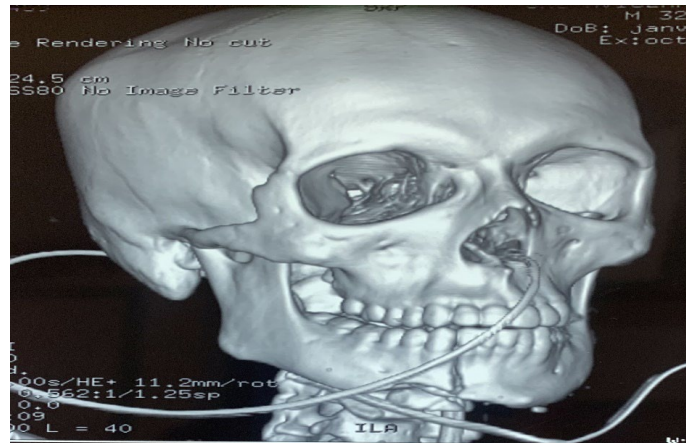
3D reconstruction CT image of the facial mass showing a right mandibular parasymphiseal fracture.
